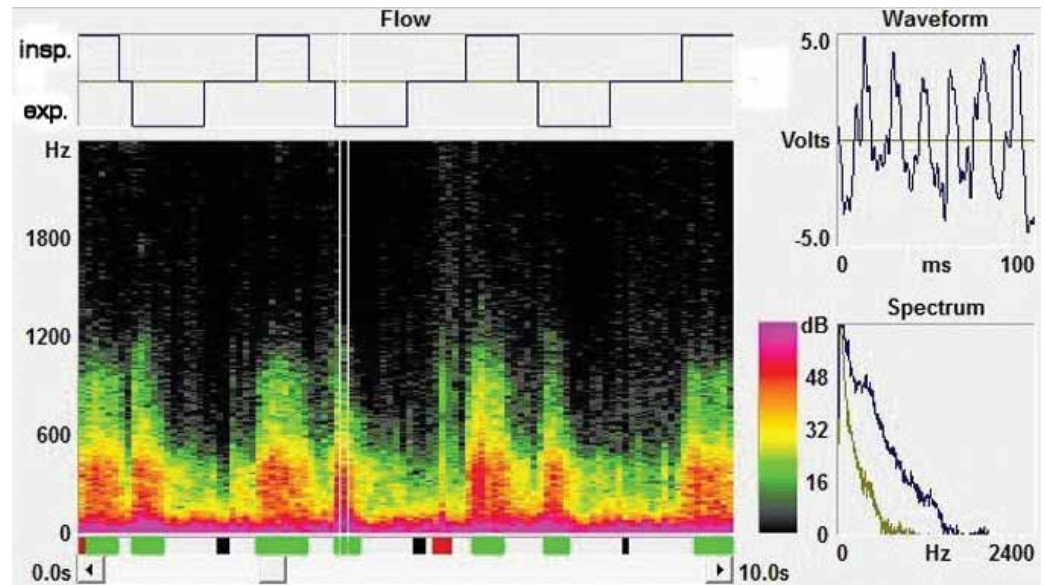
Example of acoustical analysis (sonogram). Reproduced from [21].
